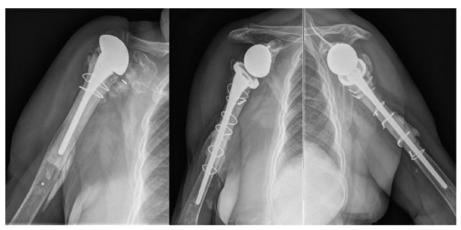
This figure shows the case of a patient with an intra-operative fracture. An anteroposterior radiograph of the right shoulder of a female patient operated for revision arthroplasty of a cemented hemiarthroplasty for post-traumatic sequelae of a proximal humerus fracture is shown (left column). Revision arthroplasty is at greater risk of suffering intra-operative fractures when compared to primary arthroplasty. When the fracture is proximal to the tip of the stem, most may be treated successfully by circumferential cerclage. In this case a long stem was used in addition to bypass a cortical window needed for cement extraction of the previous implant (middle and right columns).
